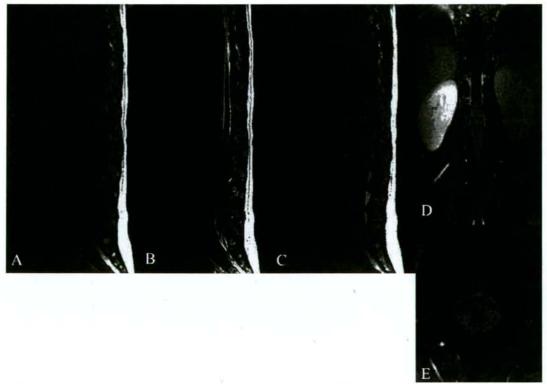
Cauda equina nerve roots were enlarged and slightly enhanced by gadolinium according to sagittal (A-C), coronal (D), and axial (E) MRI images. (A) T1-weighted image, (B) T2-weighted image, and (C-E) T1-weighted image with enhancement by gadolinium.
